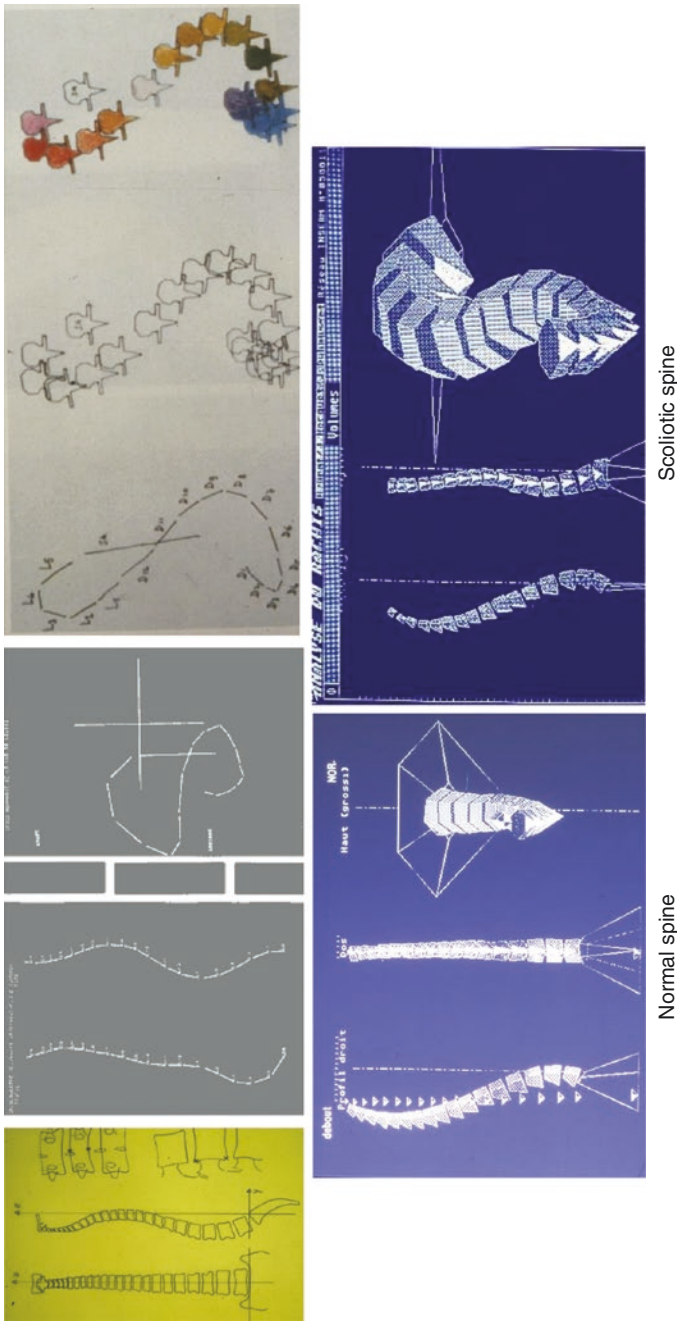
Jerome Hecquet computer reconstruction from two orthogonal X-rays of a scoliotic spine: lines first, then simple surface model, then volume. Notice the view from the top, demonstrating clearly the “piling up” of the vertebrae from feet to head
